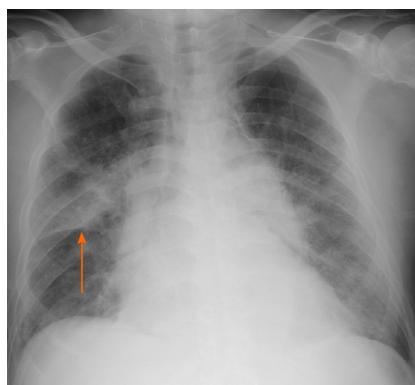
Chest radiography of a 68-year-old man with chest pain and acute dyspnea on admission. Chest radiography showing consolidation in the right upper lobe (arrow) and bilateral congestion.
